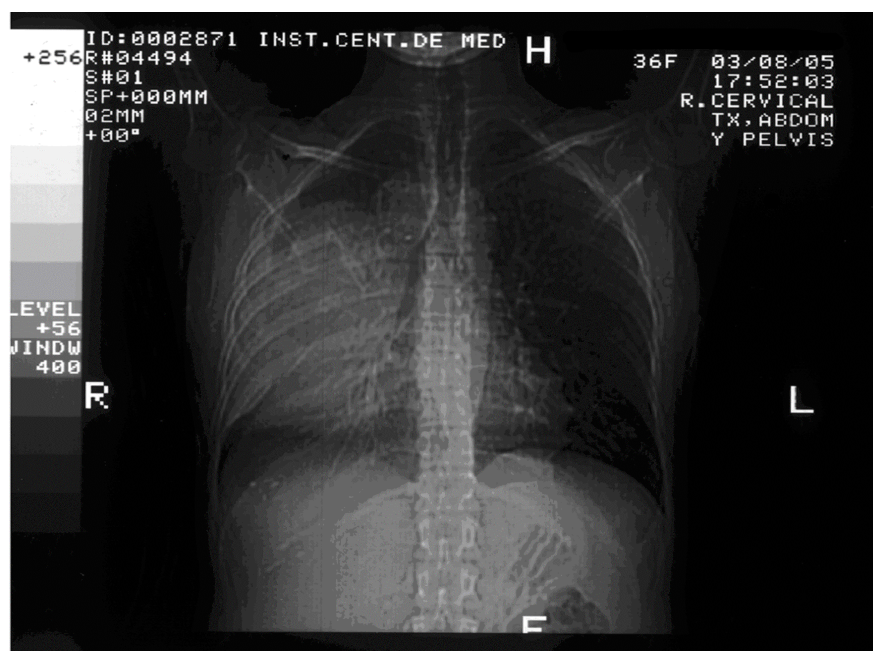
Patient 1: Initial chest CT scan
